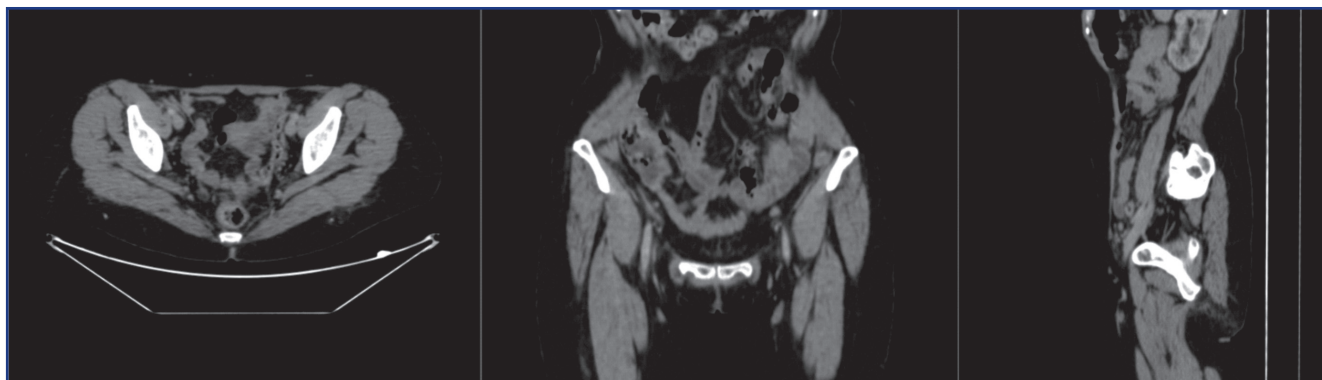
CT of the chest, abdomen and pelvis with intravenous contrast on March 04, 2024
